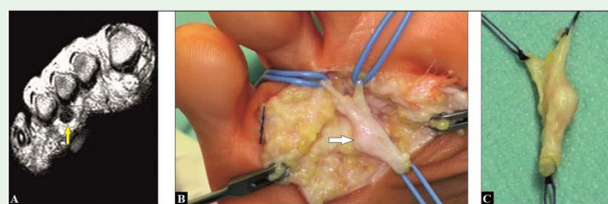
(53-year-old female, Morton's neuromas, left forefoot, plantar): (A) Preoperative magnetic resonance imaging showing the lesion between the metatarsophalangeal joints III and IV (arrow). (B) Intraoperative, dissection of the neuroma (arrow). (C) Intraoperative, after excision of the neuroma.
